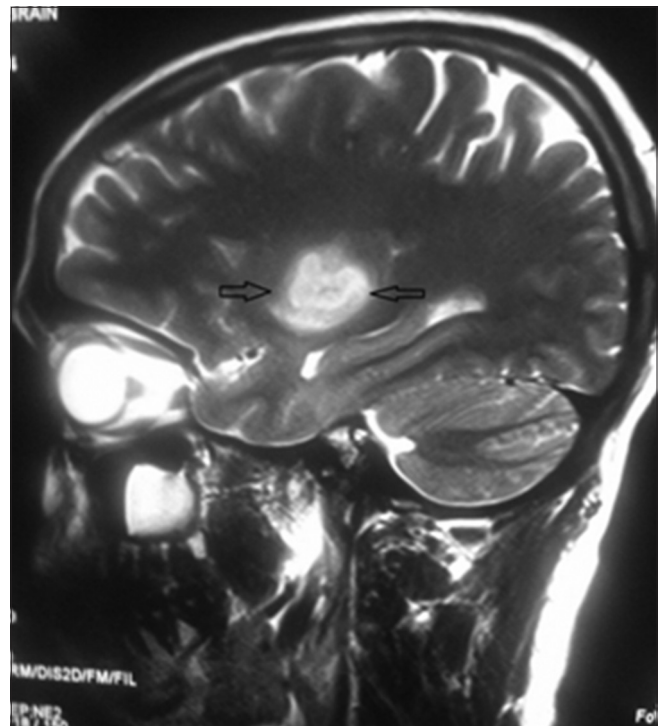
MRI brain sagittal section showing putamen necrosis
